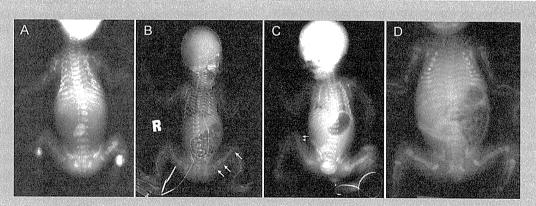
Radiographs of Patients 1 (A), 2-1 (B), 2-2 (C), and 3 (D). A: There were severe calvarial demineralization with small, dense facial bones, discontinuous beading of the ribs, and twisted long bones with multiple fractures. The metaphyses of the long bones were flared with dense transverse bands. The scapular, ischial, and iliac margins appeared irregular and sclerotic. The height of vertebrae was normal. B: Dense sclerotic bands were found in the metaphyses and fracture sites of the long bones (arrows). No vertebral compression fracture was found. The manifestation of the long bones was milder than that seen in Patient 1. C: Note mild metaphyseal sclerosis (arrow) and adjacent radiolucency (arrowhead). D: Alternating bands of radiodensity and radiolucency were found in the long bones. Osteosclerosis was particularly conspicuous in Patient 3. Discontinuous beading of the ribs and twisted long bones were noted. [Color figure can be seen in the online version of this article, available at http://onlinelibrary.wiley.com/journal/10.1002/[ISSN]1552-4833]
